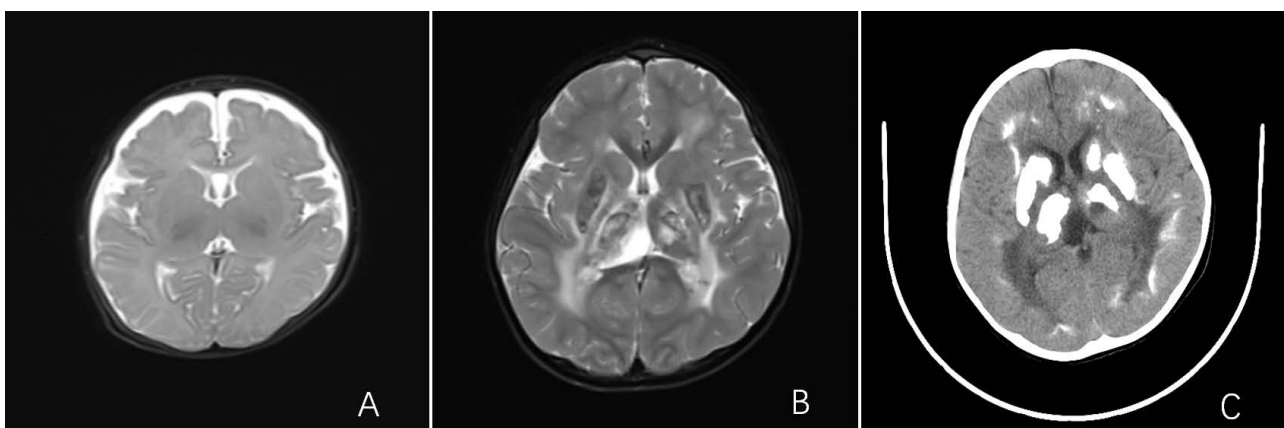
A: 2016 cranial MR sweep and diffusion-weighted imaging: widening of the extracerebral space in the bilateral frontal hazel region; B: 2019 cranial MRI sweep and diffusion-weighted imaging: multiple widespread abnormal signals in the medulla of the bilateral cerebral hemispheres, the thalamic region of the bilateral basal ganglia, the brainstem, and the bilateral cerebellar hemispheres suggestive of calcification; C: 2019 cranial CT sweep: 1. Multiple symmetrical calcified intracranial shadows. Patchy slightly hyperdense shadows in the brainstem.
